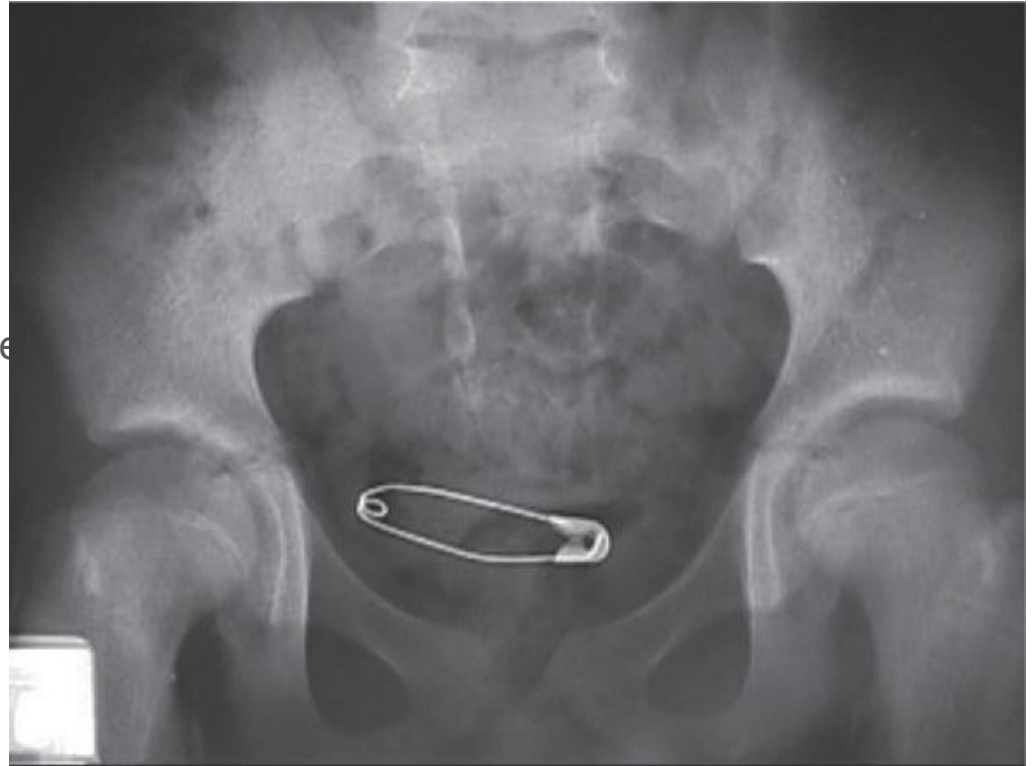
Pelvic X-ray demonstrating safety pin in vagina
